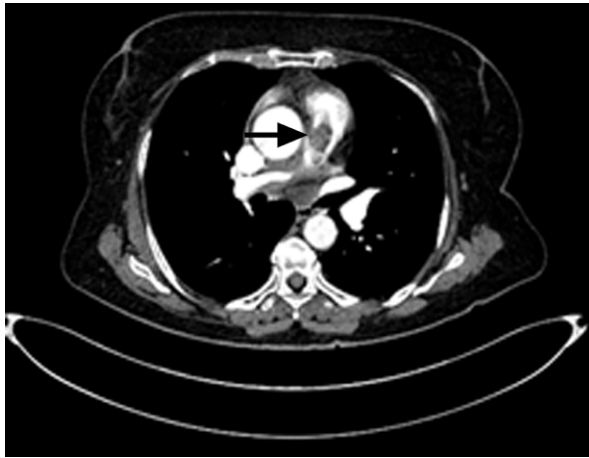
Thoracic computed tomogram shows right ventricular dilation and a mass suggestive of a pulmonary embolus (arrow) extending from the pulmonary valve into the right and left pulmonary arteries.
